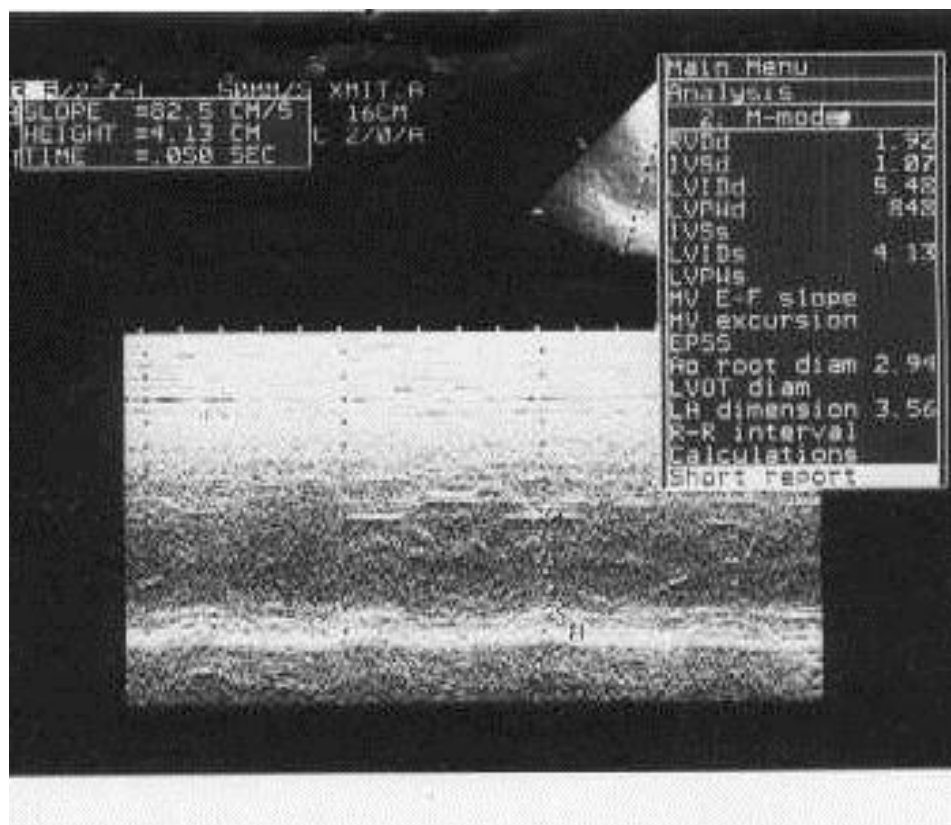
Echocardiographic measurements before and after surgery in oropharyngeal OSA (UPPP) patients
